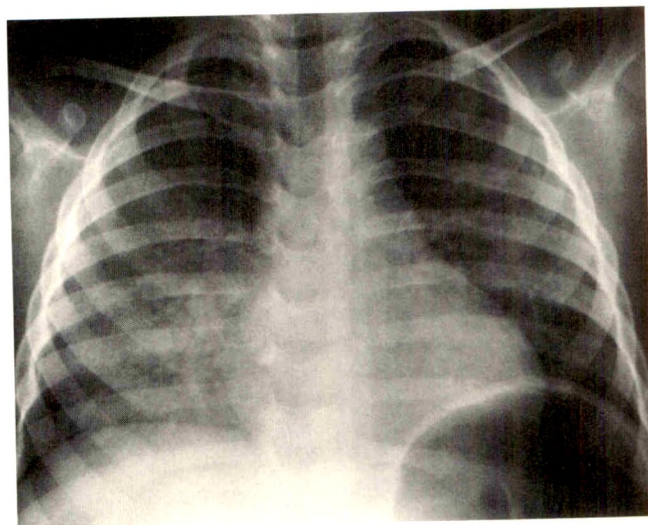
Idiopathic pulmonary hemosiderosis in a 2.5-year-old boy. Chest radiograph obtained on patient's second hospital admission shows bilateral, nonspecific infiltrates.
